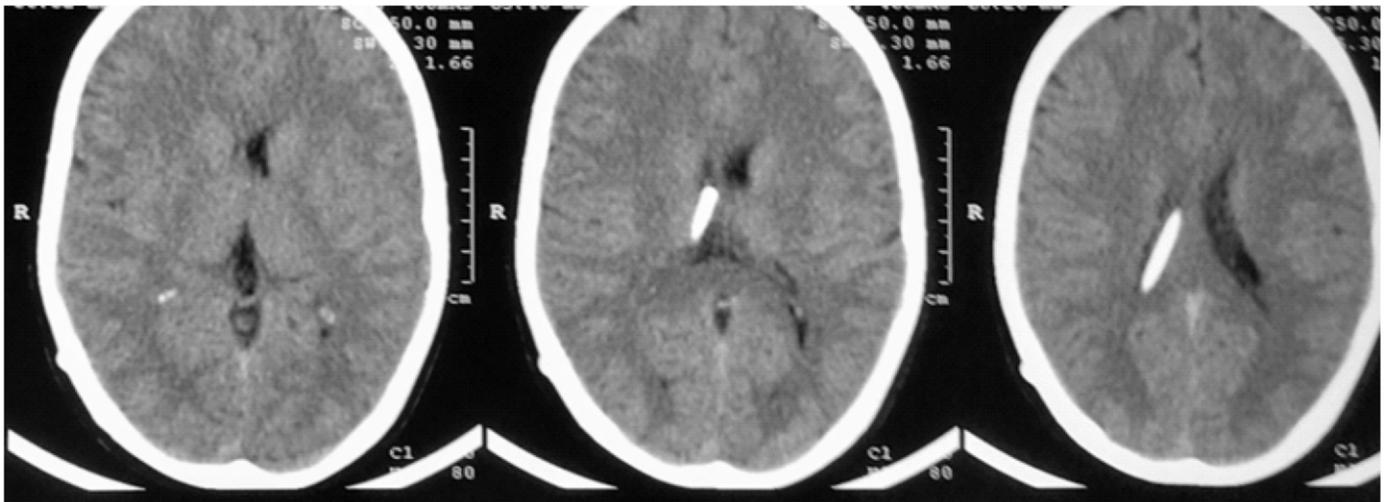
A: CT scan at the time of presentation (after first shunt).
